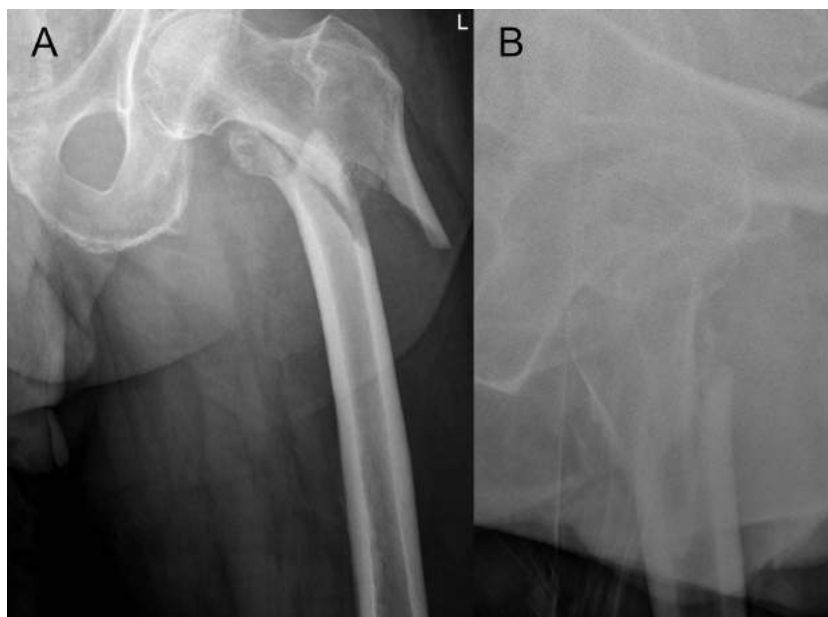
Pre-Operative X-rays for Case 3
